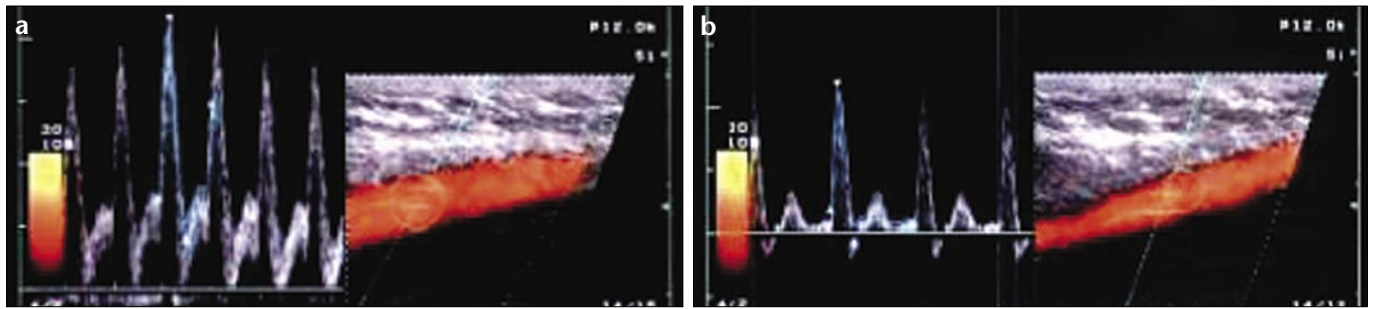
a, b. Incremental exercise protocol. a. Homogenous flow pattern in the power Doppler sonogram of the brachial artery and triphasic flow in the spectral analysis before exercise. b. Spectral analysis after exercise shows monophasic flow pattern showing increased flow velocity rate and blood flow.
